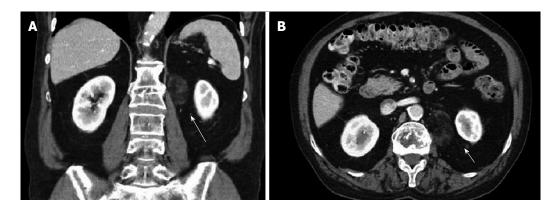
Initial computed tomography scan. Shows incidentally found non-enhancing heterogeneous mass measuring approximately 3.8 cm × 2.3 cm in longitudinal (A) and anterior-posterior dimensions (B), just inferior to the left renal vein (long arrow) and medial to the left kidney (arrow).
